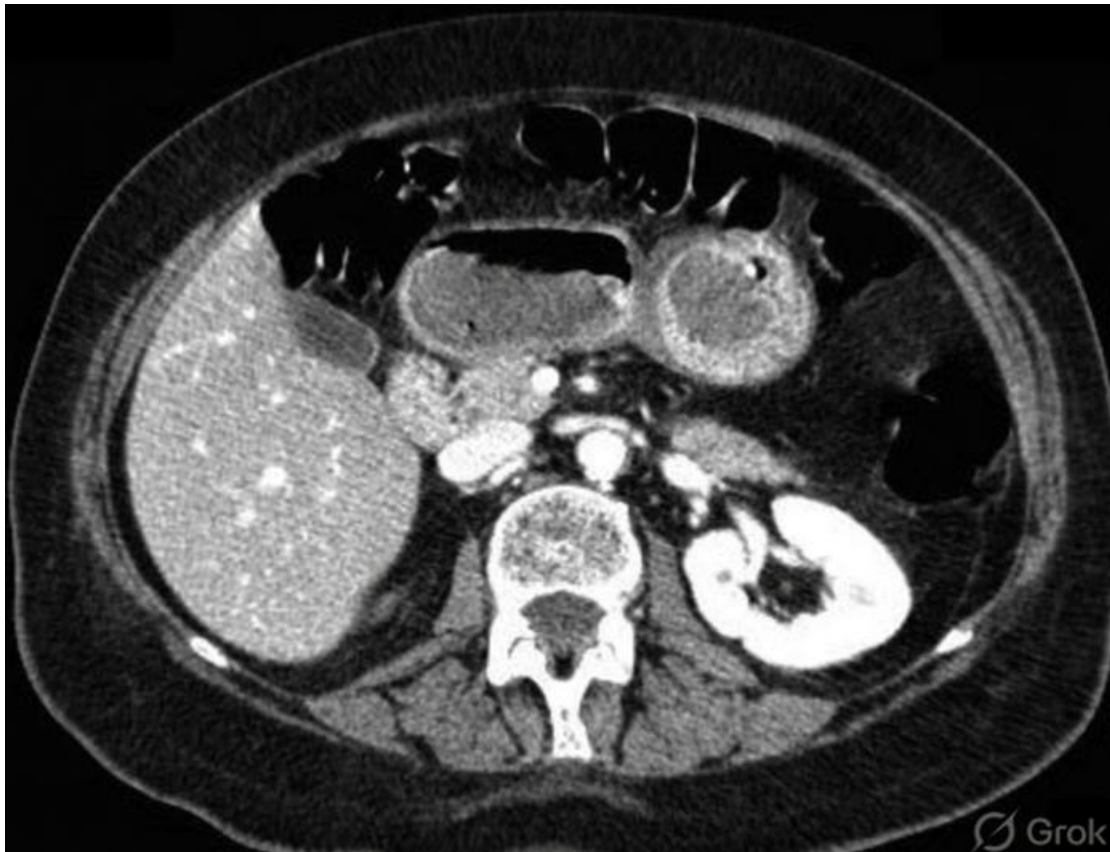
Axial contrast-enhanced CT image of the upper abdomen demonstrating an enhancing submucosal/exophytic gastric mass (consistent with gastrointestinal stromal tumour) together with additional smaller gastric lesions. The constellation of multifocal gastric GISTs in a young woman raises the possibility of Carney triad.
